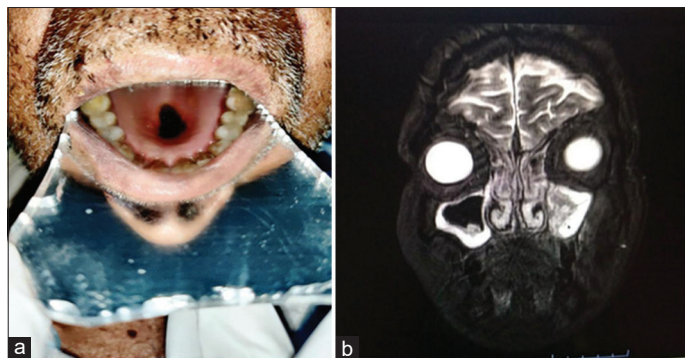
(a) Showing palatal perforation; and (b) magnetic resonance imaging image shows paranasal sinusitis on left side (Case 4)
